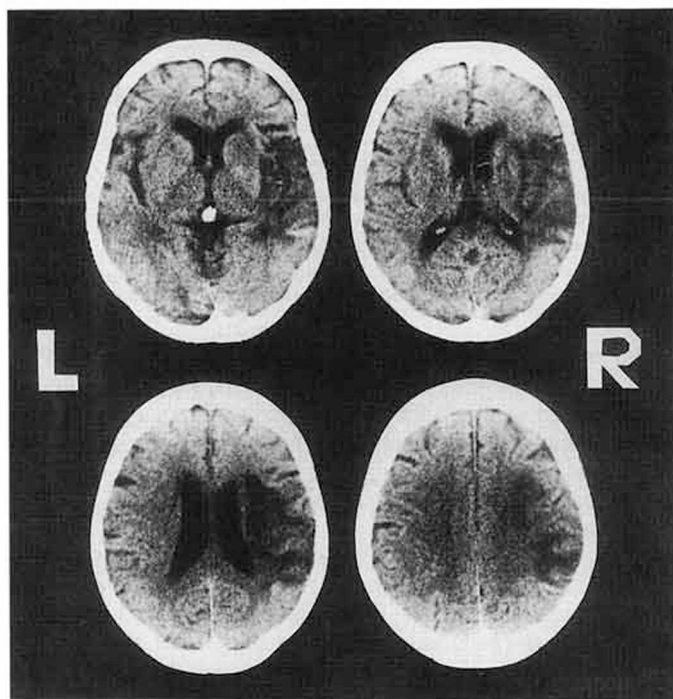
CT scan obtained on day 60 showing a large infarct in the territory of the right middle cerebral artery.
